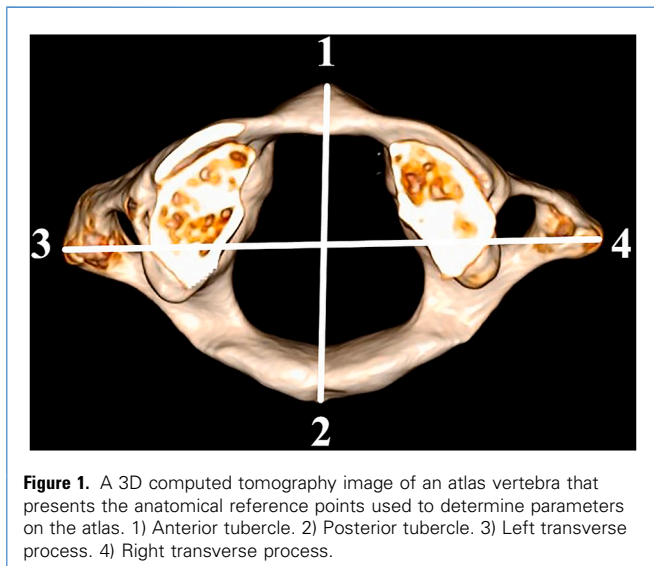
A 3D computed tomography image of an atlas vertebra that presents the anatomical reference points used to determine parameters on the atlas. 1) Anterior tubercle. 2) Posterior tubercle. 3) Left transverse process. 4) Right transverse process.
